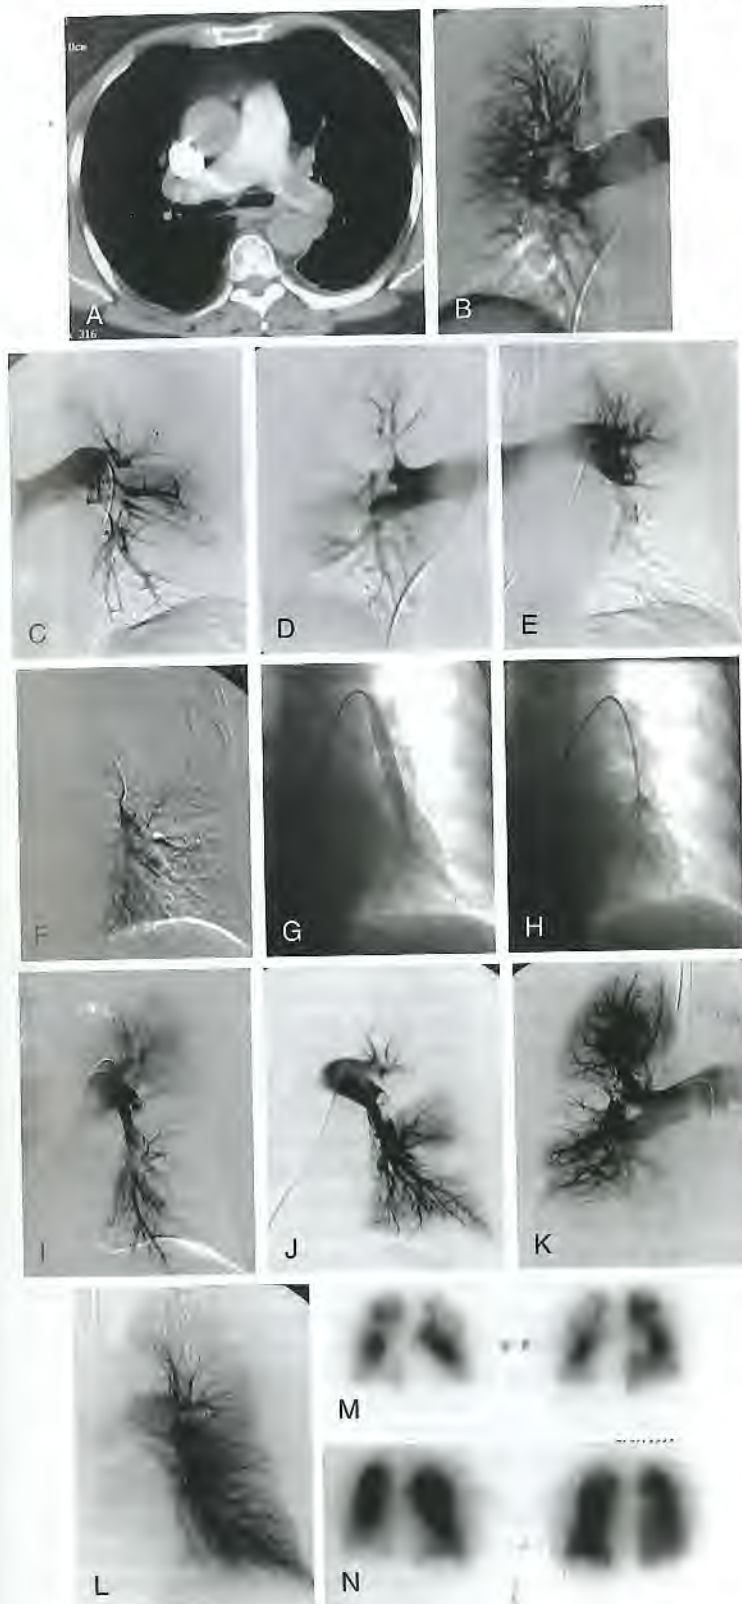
This 78-year-old woman with chronic obstructive pulmonary disease and history of myocardial infarction 1 month earlier presented to the emergency department with symptoms of deep vein thrombosis, chest pain, shortness of breath, and congestive heart failure. Chest computed tomographic angiography (CTA) was positive for acute pulmonary embolism. Ventilation/perfusion scan showed massive perfusion defects. Patient was transferred to our hospital, and a pulmonary arteriogram was requested for possible catheter-directed treatment. A, Chest CT scan showed large filling defects in both main pulmonary arteries. After hemodynamic stabilization, a pulmonary arteriogram was performed. B, Right pulmonary arteriogram showed severe obstruction at the bifurcation of the right main pulmonary artery (PA). There was reduced perfusion of the right upper lobe and marked hypoperfusion of the right lower lobe. C, Left pulmonary arteriogram showed a large embolism involving the left lower lobe with marked reduction in peripheral perfusion. Pulmonary artery pressure (PAP) was 39 mmHg. D, Follow-up right pulmonary arteriogram after 15 hours of catheter-directed thrombolytic infusion showed marked improvement of the obstruction, with some residual clots involving the right upper and middle lobes. There was interval improvement in right lower lobe perfusion. E, Follow-up left pulmonary arteriogram showed progressive occlusion of the left lower lobe likely from distal migration of a proximal thrombus. PAP was 46 mmHg. F, Selective catheterization of the left lower lobe branch through the clot was performed and showed total occlusion of the lower lobe artery. G, A 10-mm balloon catheter was advanced into the lower lobe branches over a wire and used to fragment clot. H, An occlusion balloon was tumbled back several times to further fragment the clots. I, An angiogram after mechanical balloon thrombectomy showed improved lower lobe segment patency. A catheter was placed within the partially occluded artery, and thrombolytic infusion was continued. J, Follow-up left pulmonary arteriogram after 15 hours of local thrombolytic infusion showed significant improvement in left lung perfusion. K, Final right pulmonary arteriogram showed significant improvement in right pulmonary perfusion. L, Final left pulmonary arteriogram showed near complete patency of the left PA and peripheral branches. Mean PAP after treatment was 33 mmHg. The patient improved clinically, was weaned off the ventilator, and successfully extubated. M, Pretreatment perfusion scan showed multiple wedge-shaped areas of segmental hypoperfusion. N, Perfusion scan 3 days after catheter-directed thrombolytic therapy showed remarkable improvement in bilateral pulmonary perfusion. After discharge from the intensive care unit, the only complication was acute renal failure that eventually resolved after 5 days, with return of creatinine to normal levels. The patient was discharged home within 1 week after receiving catheter-directed therapy.
